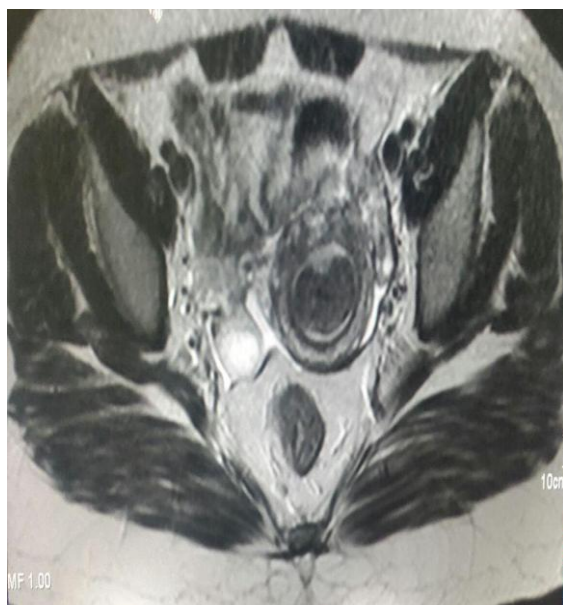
MRI axial T2 W image of submucosal fibroid. Showing a well marginated typically hypointense lesion within the endometrial cavity.
